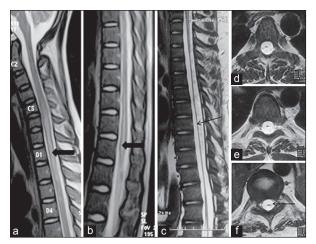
T2 weighted cervical (a) and dorso-lumbar (b) MRI of the patient showing continuous hyper-intense signal from C4 to conus medullaris (thick arrows). MRI done 5 years later shows thread-like atrophic spinal cord (thin arrow) extending from D3 to conus medullaris in sagittal T2 (c) and three different dorsal planes of axial T2 (d, e, f) weighted images
